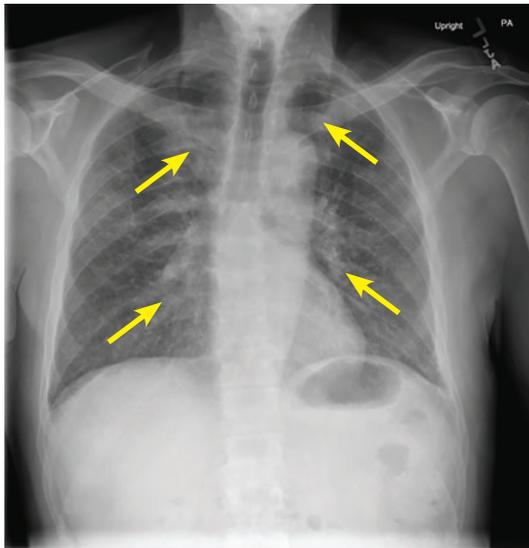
Initial radiography showed diffuse interstitial infiltrates.
